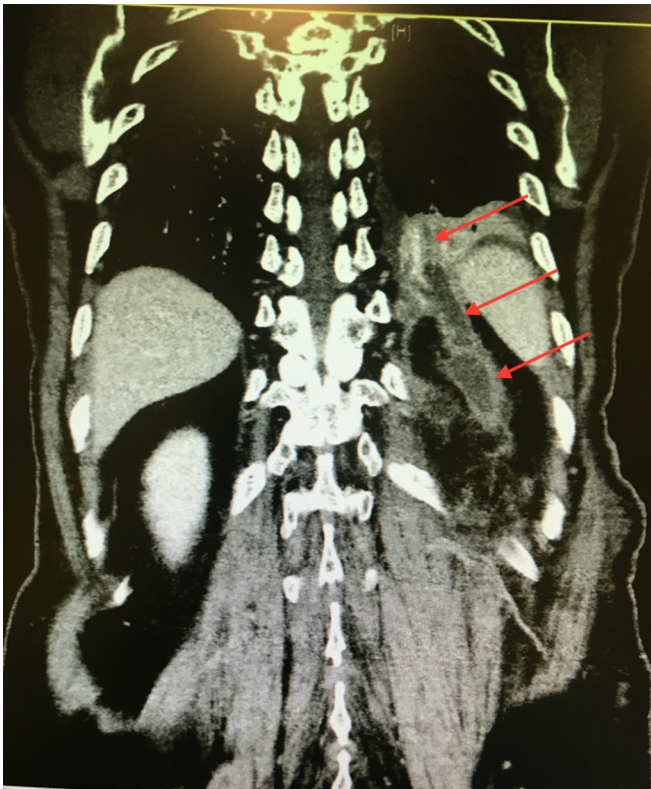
Post-operative CT showing nephrobronchial fistula tract.
